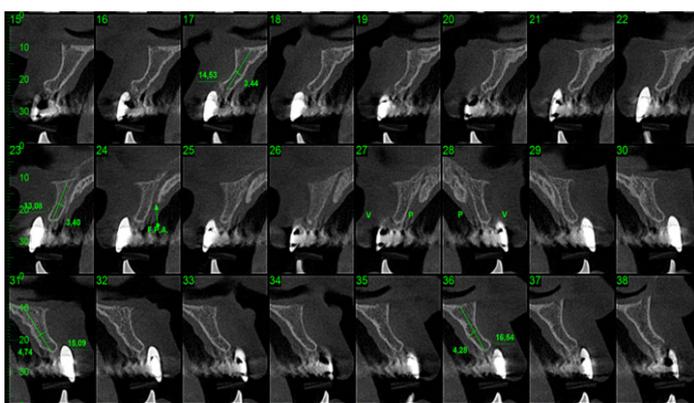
Computed tomography, transverse sections of anterior maxilla.
